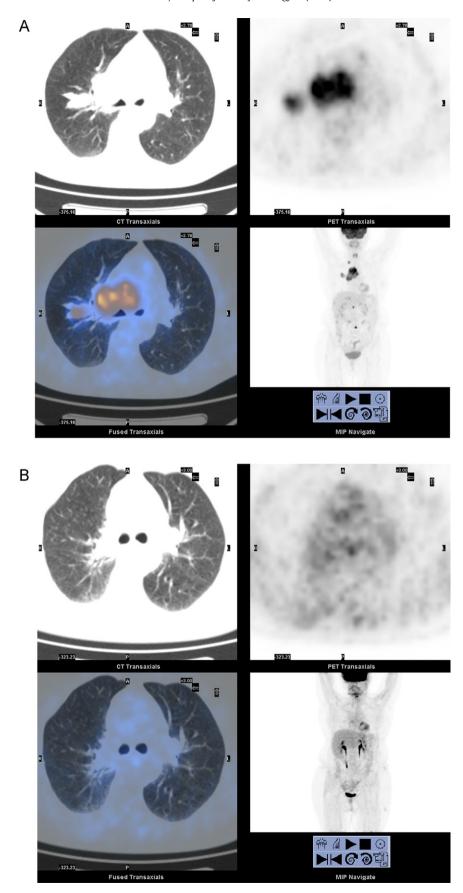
18F-FDG PET/CT images of a patient with SCLC studied before (A) and after (B) treatment. Pre-treatment evaluation (A) revealed a left hilar mass with multiple hypermetabolic lymphnodes and multiple bone lesions. PET/CT imaging after chemotherapy (B) shows a complete response.
